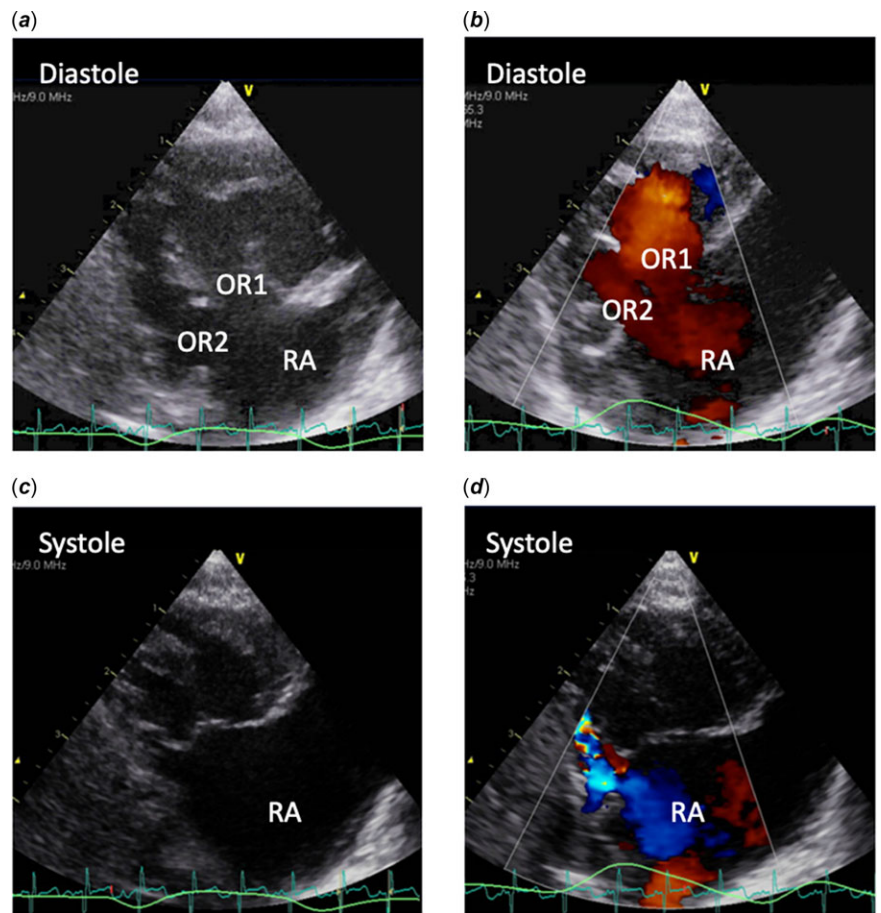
2D and colour Doppler images of the right ventricular inflow in the parasternal long axis. Panel A and B shows the separate orifice in 2D and the double inflow pattern during diastole. Main orifice (OR1), accessory orifice (OR2). Panel C and D shows the separate orifice in 2D in systole as well as the regurgitation jet from the smaller orifice. RA = right atrium.
